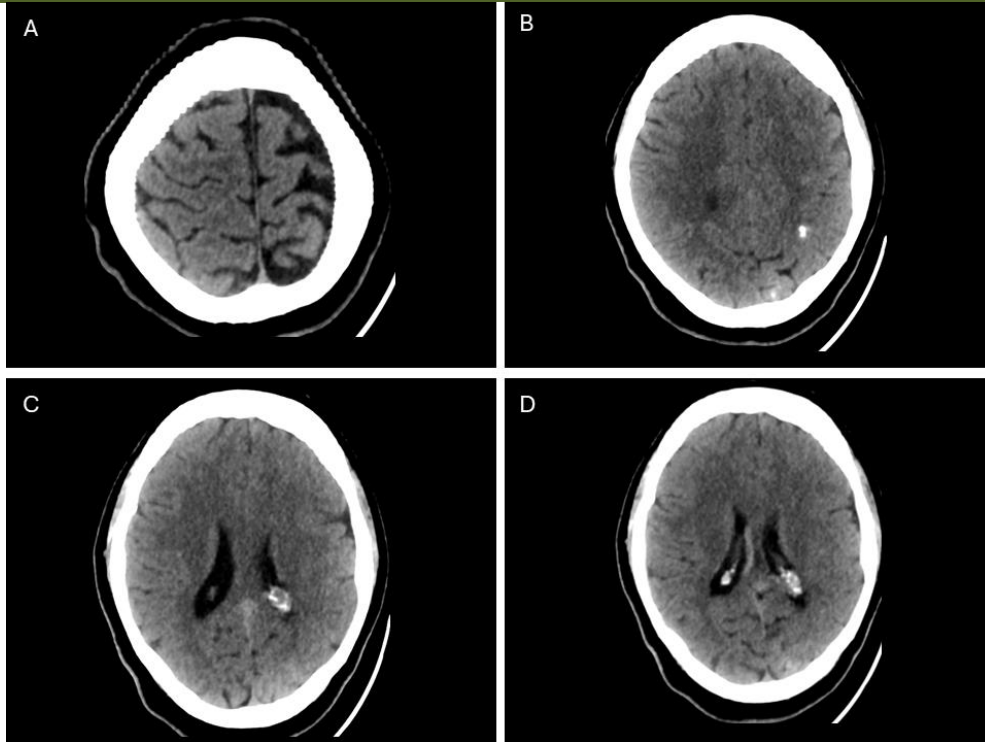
Non-contrast brain CT images.
